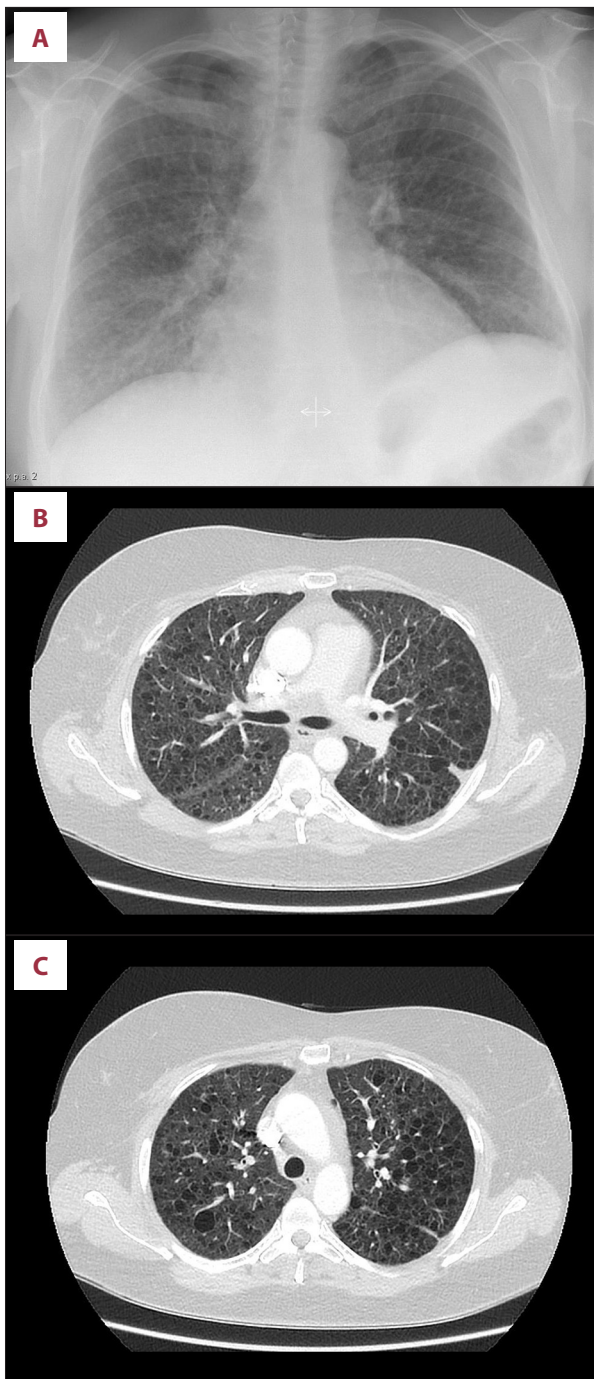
Chest X-ray and computed tomography (CT) images of the lung in a 47-year-old female patient with lymphangioleiomyomatosis (LAM). (A) Chest X-ray shows diffuse reticular opacities throughout both lungs. (B, C). Computed tomography (CT) scan shows numerous thin-walled cysts within the lungs and diffuse ground-glass opacities, characteristic for lymphangioleiomyomatosis (LAM).
